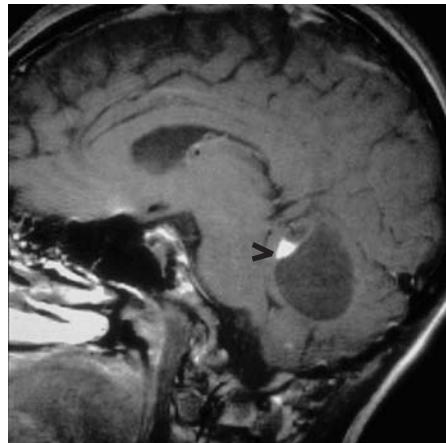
Lateral MRI view of a cerebellar haemangioblastoma showing the hyperdense tumour nodule (arrow) and a large adjacent cyst.
